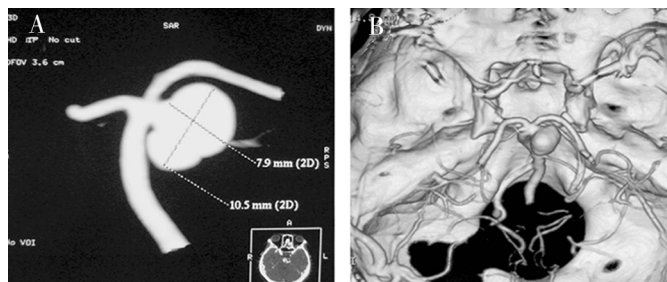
CT with MIP (A) and SSD (B) reconstruction images displayed that aneurysm was obviously regressed to 0.9 cm in diameter
